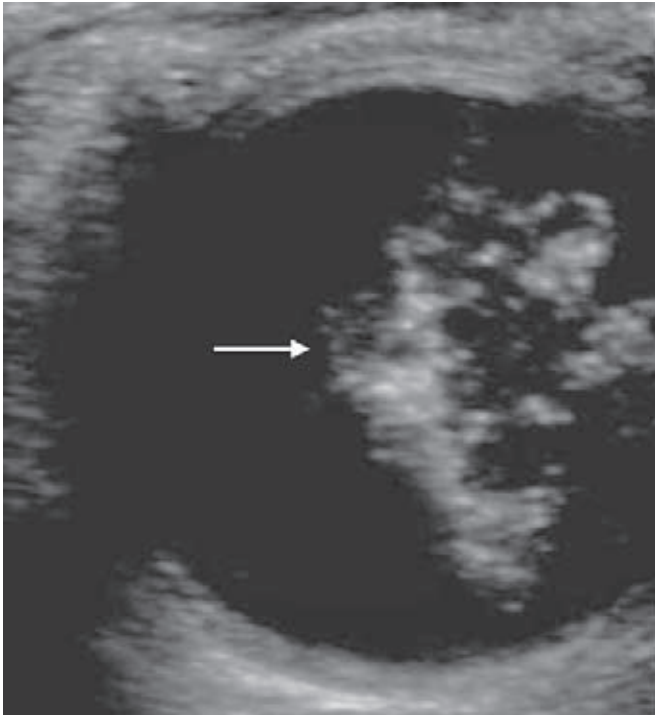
Retinoblastoma. Ultrasound scan of right globe reveals an irregular mass (arrow) containing multiple specks of calcification
